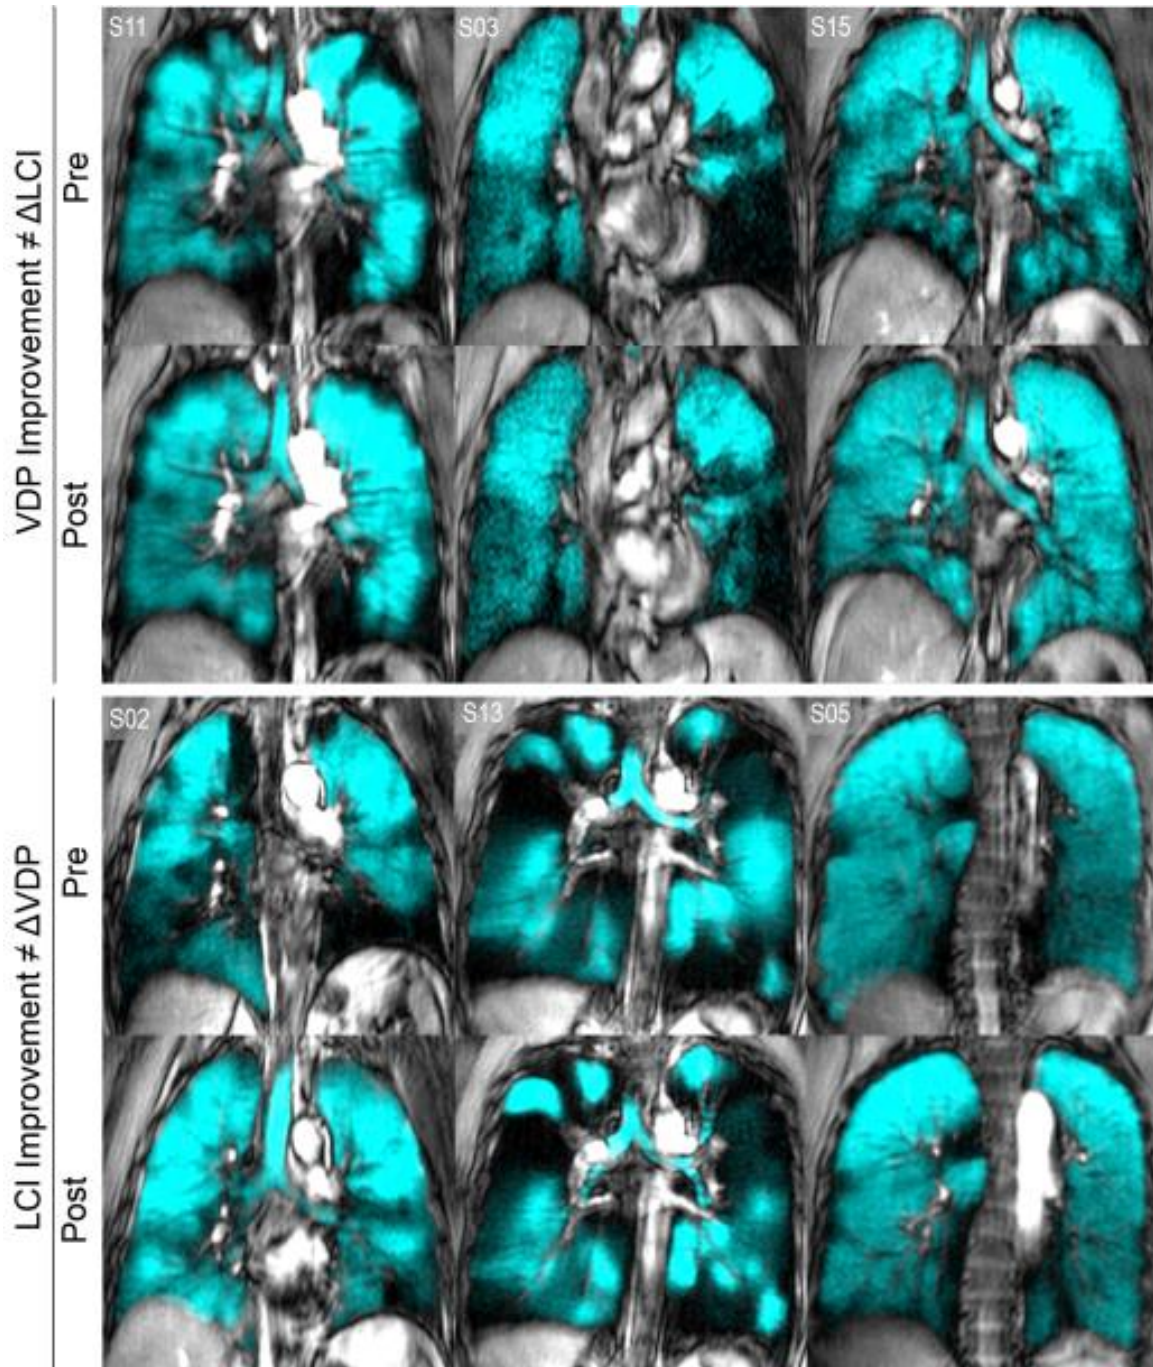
Pre- and post-bronchodilator ^3He ventilation MRI.
